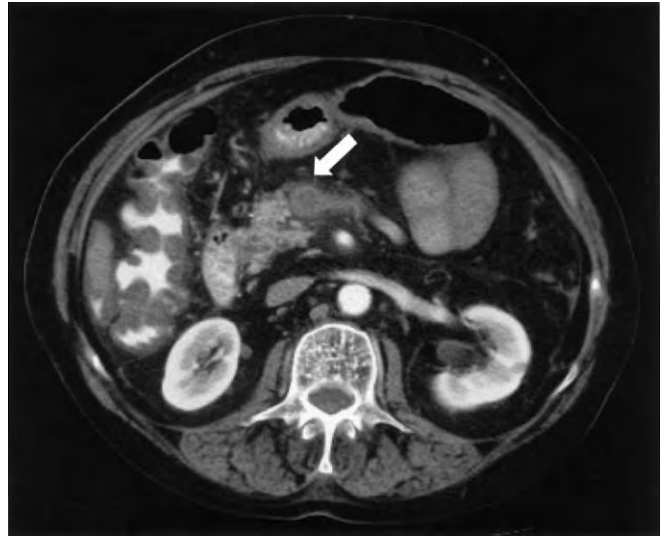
Computed tomographic scan of a patient with mesenteric venous thrombosis showing a thrombosed superior mesenteric vein at the splenic vein junction (*arrow*), streaking of the mesentery, and bowel wall thickening.
